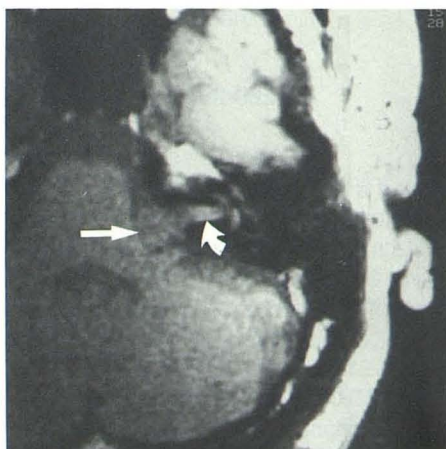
Cerebellopontine angle meningioma (*black arrow*) in axial short TR and TE MR image (A) found to be entirely extracanalicular at surgery. Its edge (*curved arrow*) at porus acusticus is shown. In coronal short TR and TE image (B) normal cranial nerves in ipsilateral canal are identified (*white arrow*). Thin region of negligible signal between them probably represents falciform crest. A long TR and TE image was not helpful in defining the extent of tumor.
